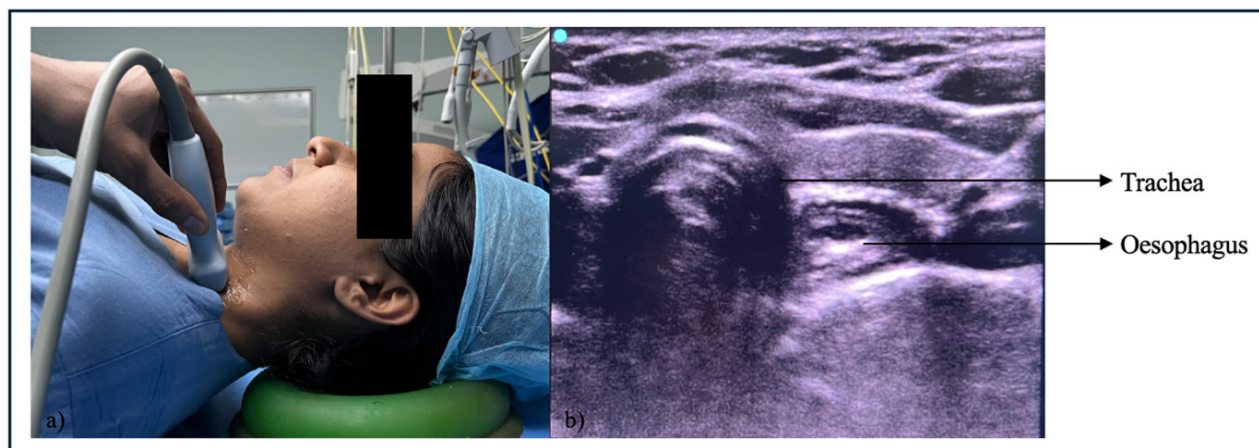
a) Scanning technique to visualize the trachea and esophagus. b) ultrasound image showing the trachea and esophagus in the same field
